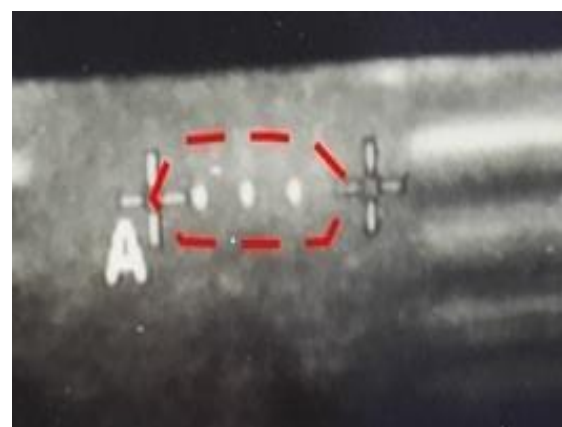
Ultrasound image of cartilage volume 6 months after surgery (Longitudinal dimension of cartilage marked with white dotted line and cartilage border with red dotted line)
